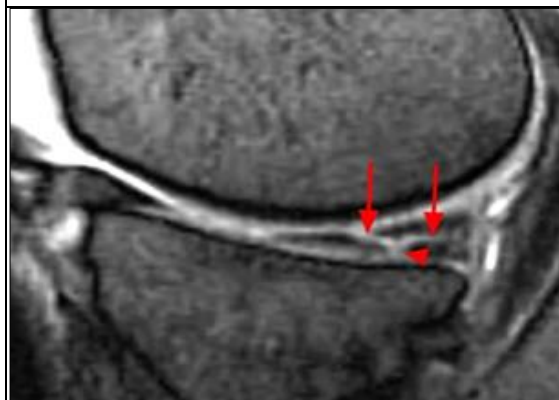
MRI T₂*GRE weighted sagittal image shows complex tear of posterior horn of meniscus, having horizontal and longitudinal components
